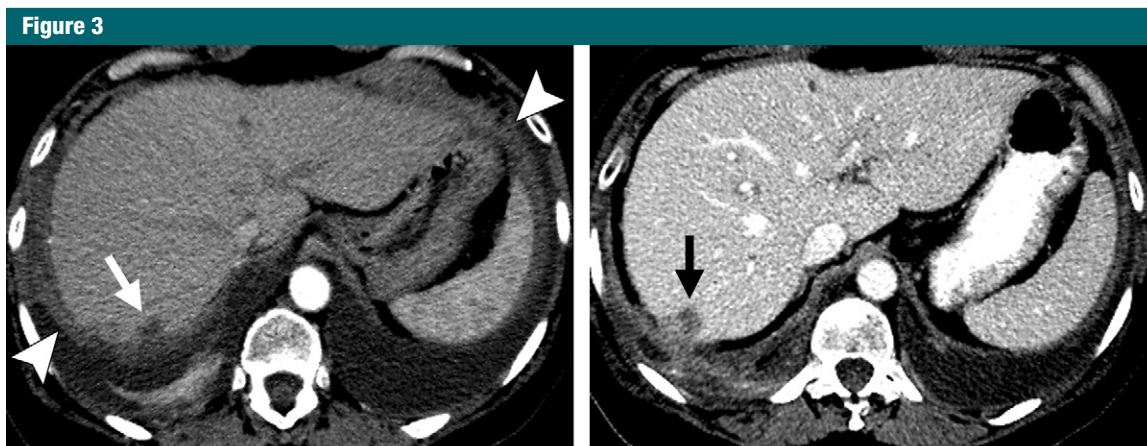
Axial contrast-enhanced CT scans in a 68-year-old patient with low-grade serous adenocarcinoma. (a) Image shows small-volume upper abdominal ascites (arrowheads) and (b) image obtained 2 months later. There was a perihepatic metastasis (arrow) in segment 7 that increased in size and developed an invasive component between the two axial CT scans, with agreement between all reviewers.
